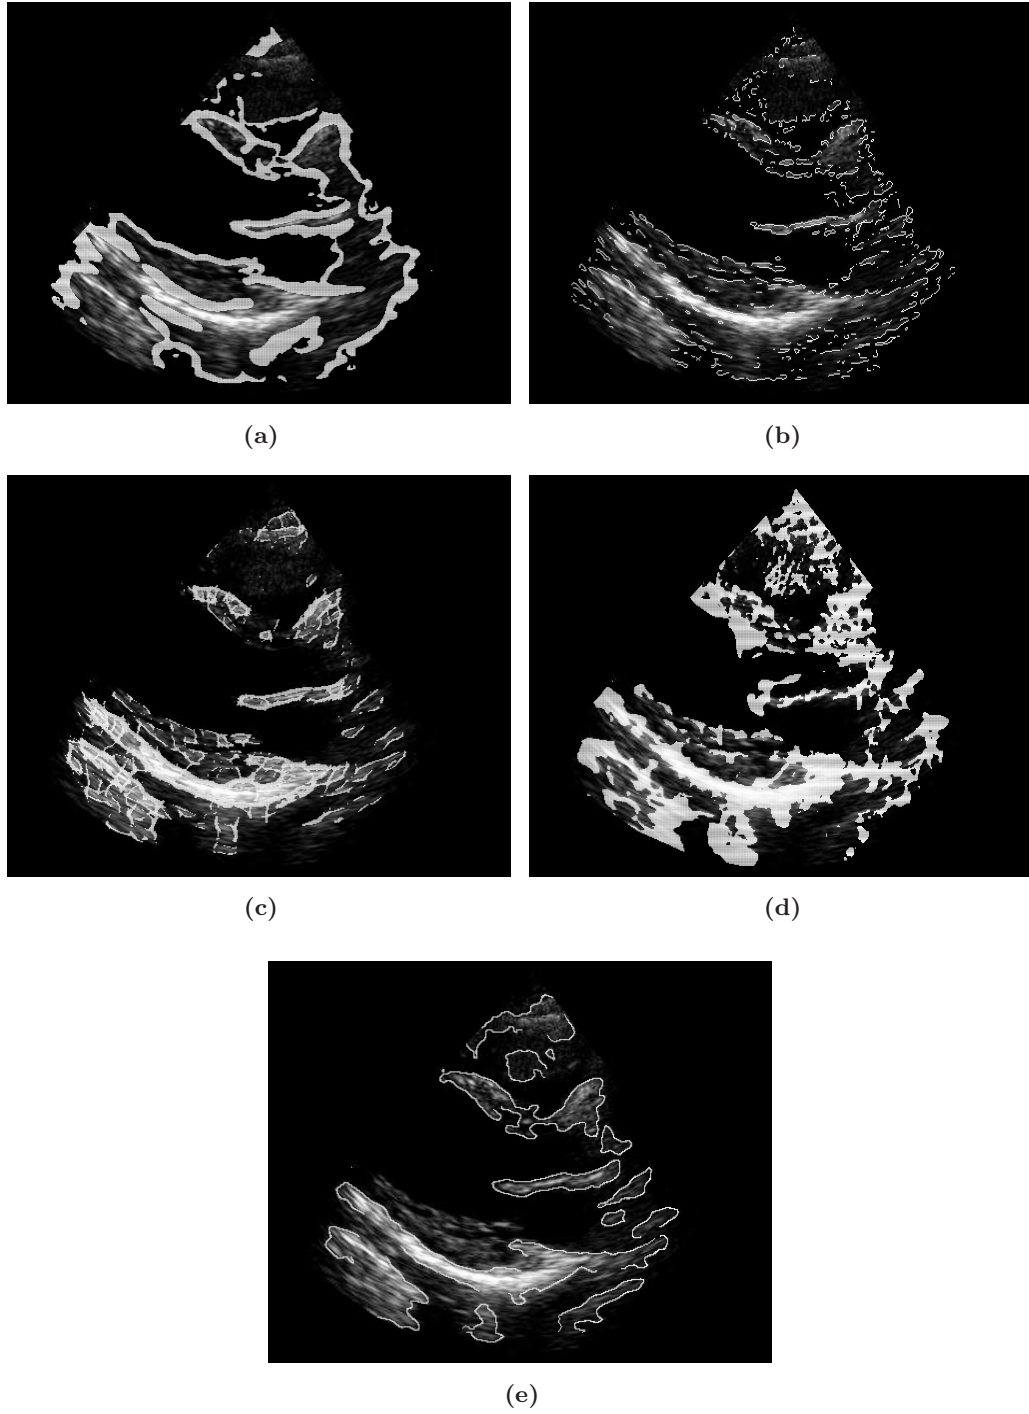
Edge detector output for the clinical ultrasound images of Fig. 6.8(b). (a) CV, (b) RoA, (c) FA, (d) PC, (e) ZC.
